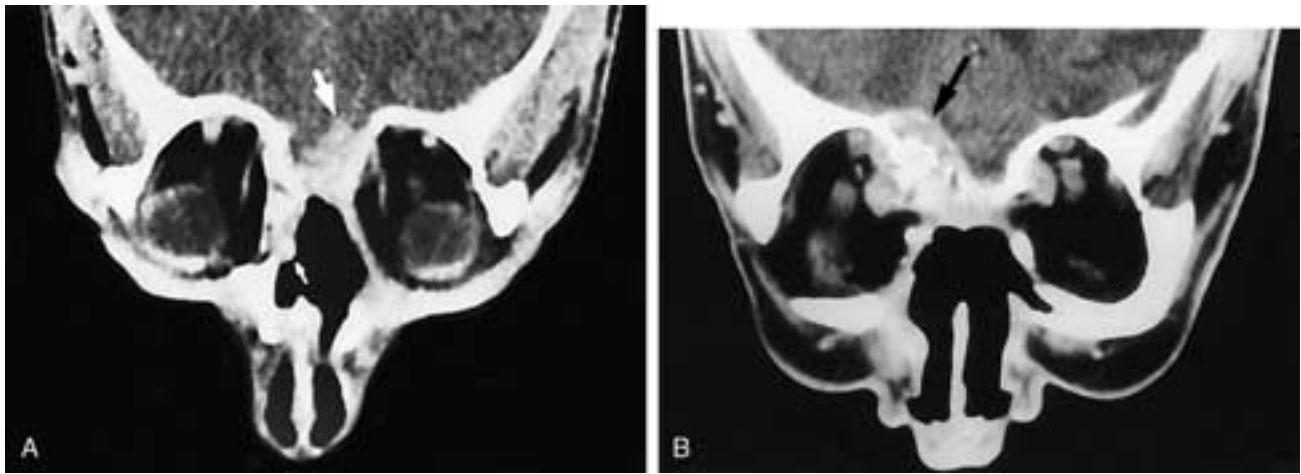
Coronal contrast-enhanced CT scan (A) on patient who has had a craniofacial resection. The upper fascial-muscle graft contour is nodular (*arrow*). This should raise the suspicion of early tumor recurrence. This patient had recurrent tumor. Coronal CT scan (B) on a patient who has had a craniofacial resection. There is a soft-tissue mass (*arrow*) along the graft margin in the floor of the anterior cranial fossa. The mass has also invaded the right orbit. This patient had recurrent adenocarcinoma.
